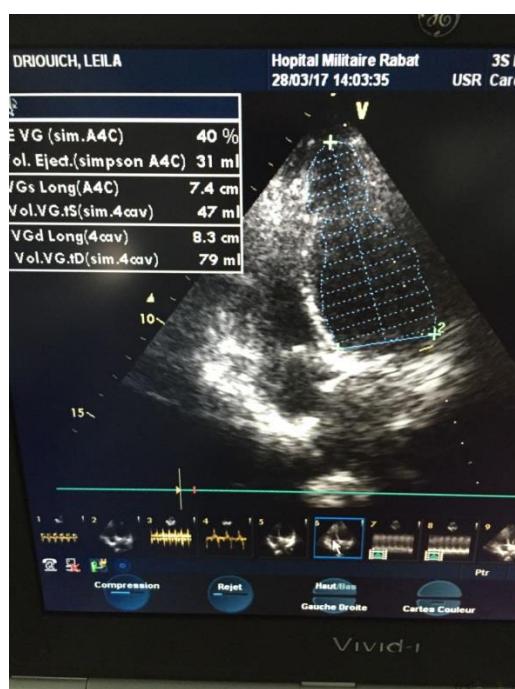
Echocardiography: 4 cavities cut showing an apical balloonization of the left ventricle
